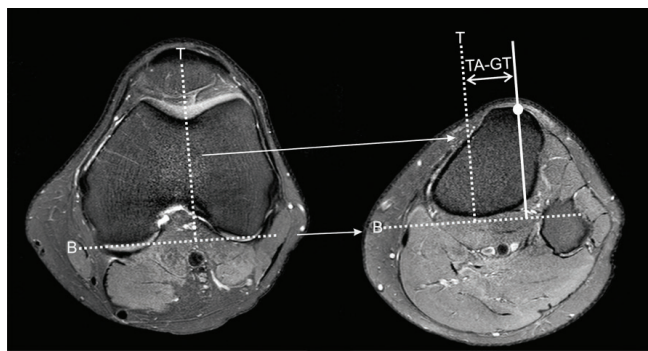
T2-weighted MRI with fat suppression in the axial plane, in extension, showing measurement of the TA-GT distance. Firstly, a line was traced out tangentially to the posterior femoral condyles (dashed line B), which was extended to the image in the plane of the anterior tuberosity of the tibia. Following this, two lines perpendicular to the posterior bicondylar line were traced out: one going through the center of the base of the trochlea (dashed line T), which was also extended; and the other (straight line) going through the center of the patellar ligament (circle), in the plane of its uppermost insertion into the tuberosity of the tibia. The TA-GT distance (double arrow) is the distance between these two lines, which are parallel to each other.
